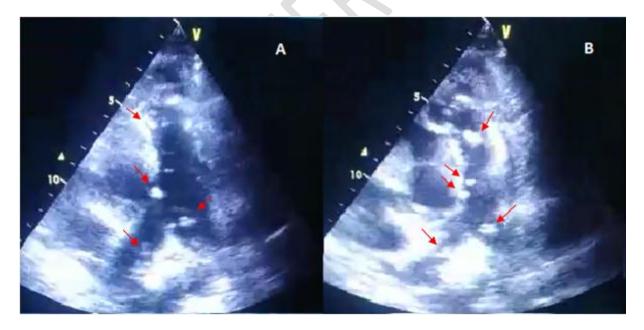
Transthoracic echocardiography short axis view (A) During systole (B) during diastole, showing vegetations along the pulmonary ejection pathway
